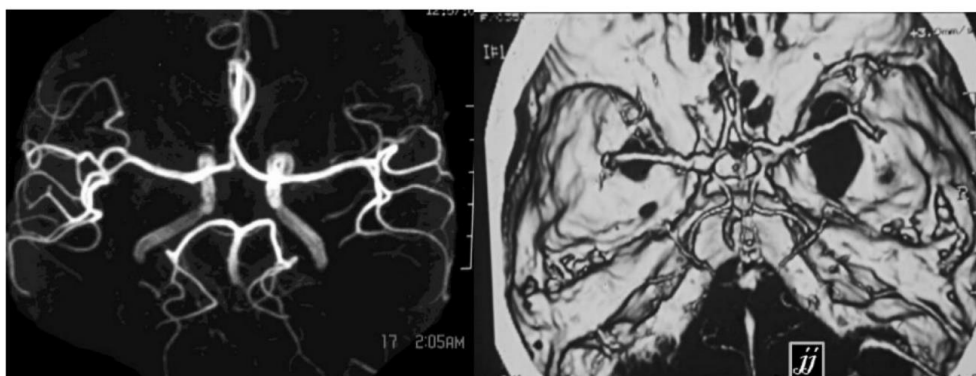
non--contrasted MRA and Axial CTA show Willis Circle
